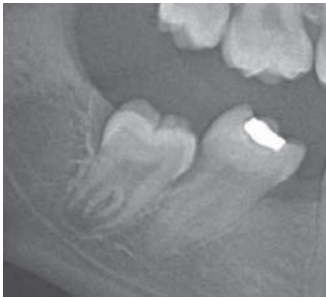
Pathology associated with impacted mandibular third molars: radiograph of root resorption of second mandibular molar as result of semi-impacted third molar.
